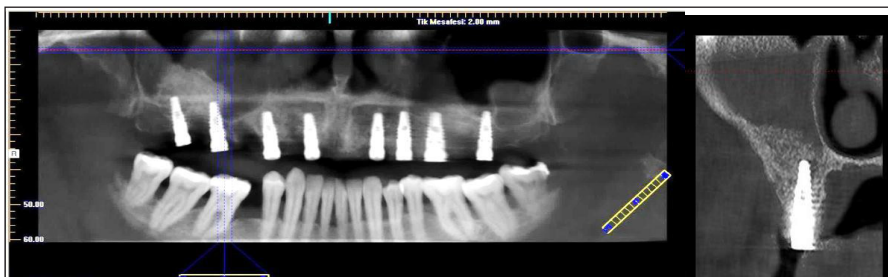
Radiographic appearance after implant insertion.
